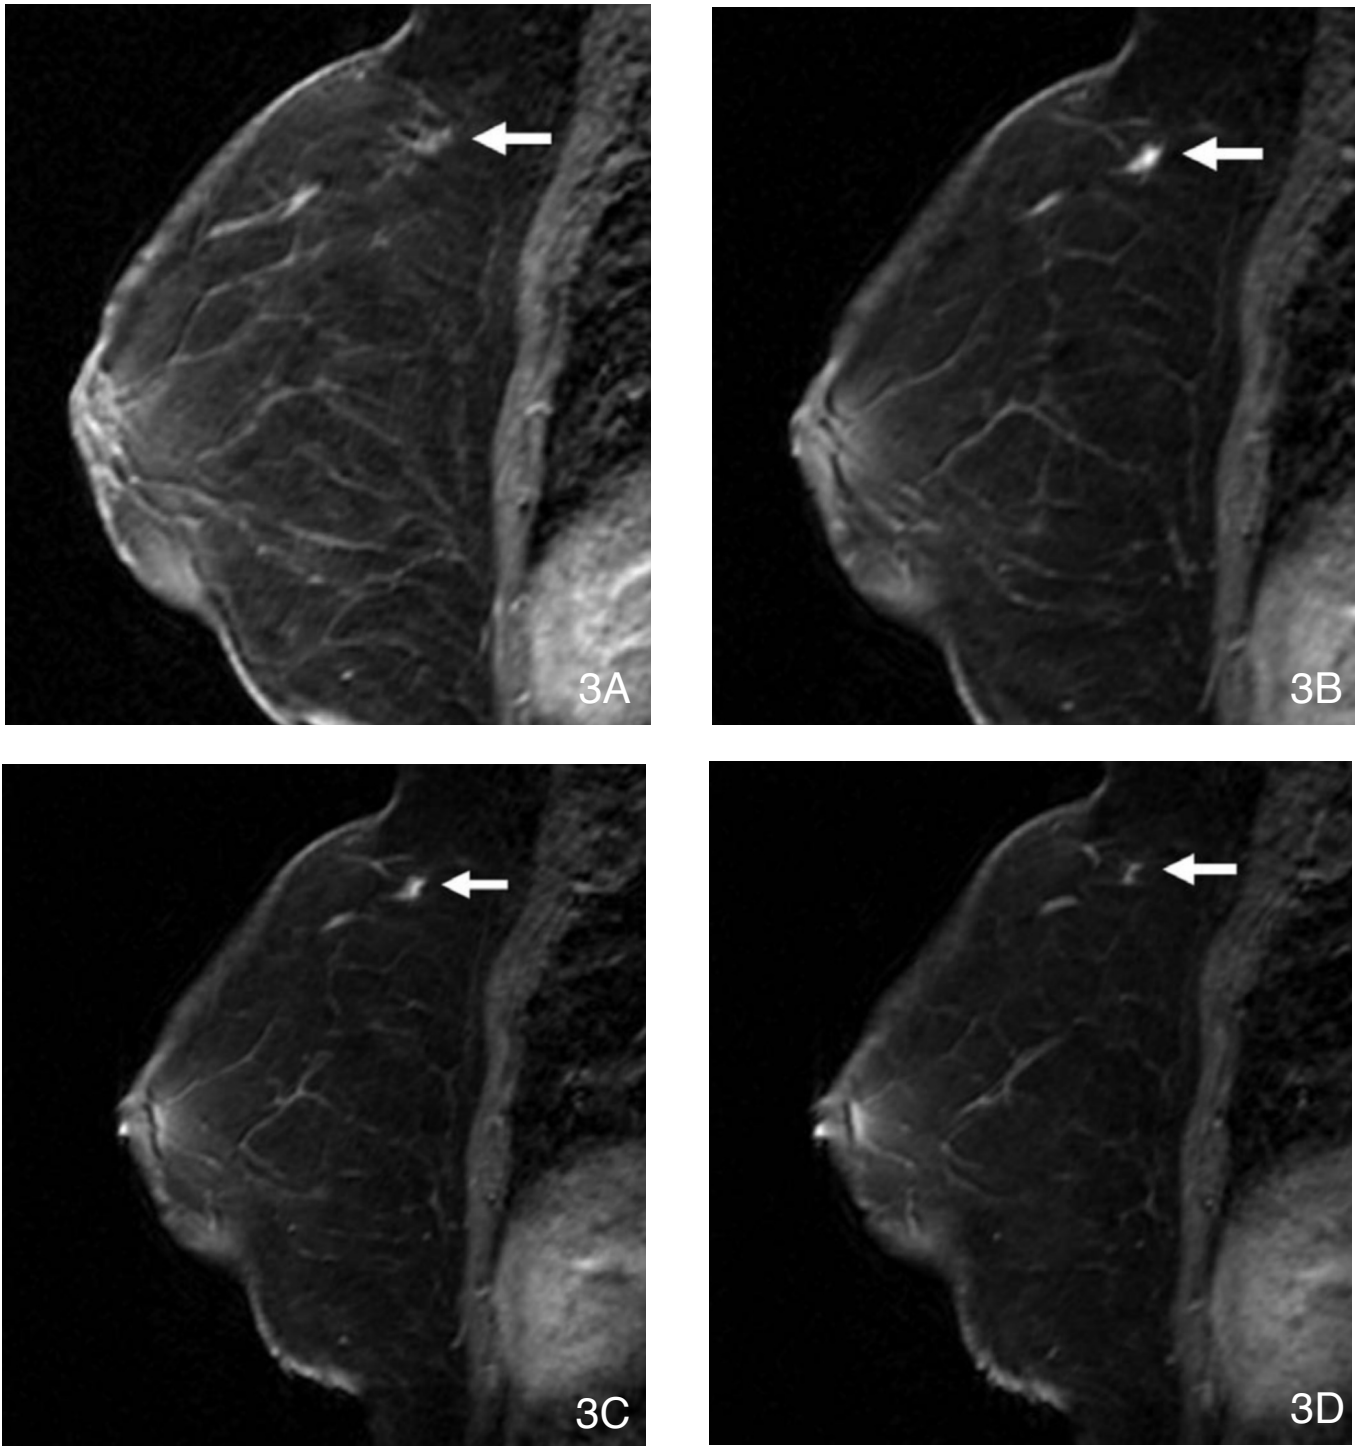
(A-D). Six weeks after the initial breast MRI, a repeat study for the purpose of needle localization was performed. Four sequential frames using the same slice thickness in the same location from a T1-fat-suppressed imaging obtained two minutes after contrast injection demonstrate significantly diminished size and enhancement of the mass (arrow). The breast anatomy appears slightly different due to light compression placed during the needle localization procedure.
